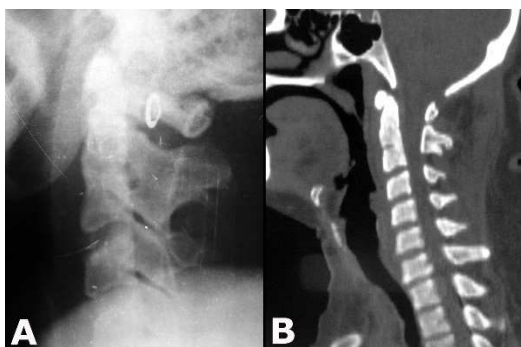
(A) Lateral x-rays and (B) CT scan of the cervical spine showing C2-3 vertebral body fusion with waist formation
